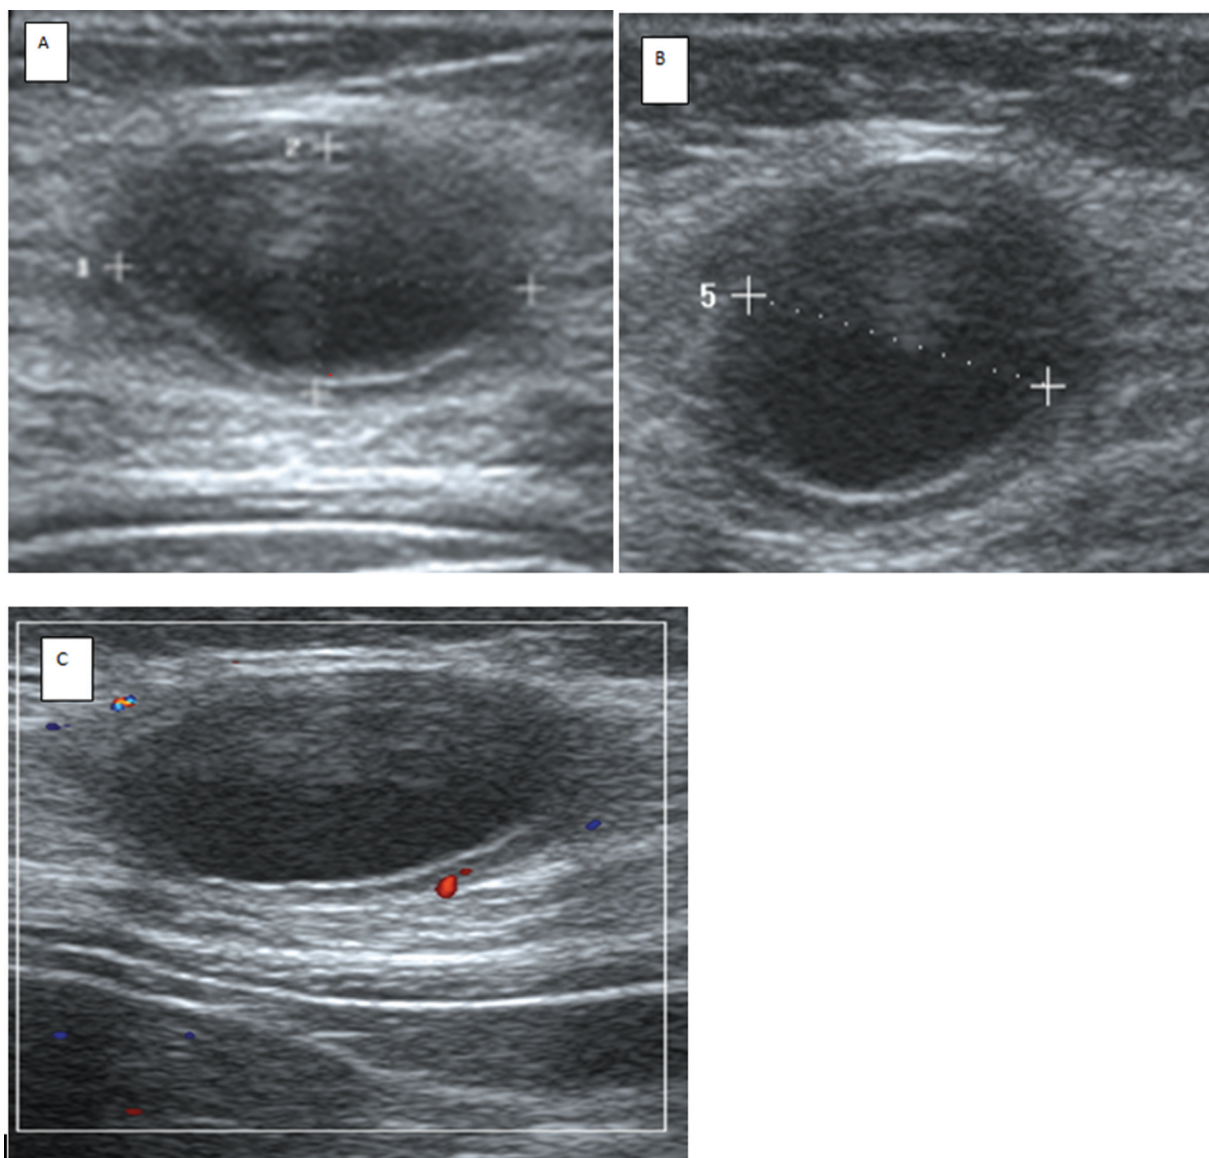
(A) Longitudinal view on ultrasound reveals a well-defined cystic lesion measuring $\sim 2.6 \times 1.5 \times 1.6$ cm with perceptible wall noted in the intramuscular plane of the right upper quadrant of the anterior abdominal wall. There is no evidence of internal vascularity/echogenic content/calcification within the lesion. (B) Axial section of the same lesion. (C) On color Doppler there is minimal peripheral vascularity.
